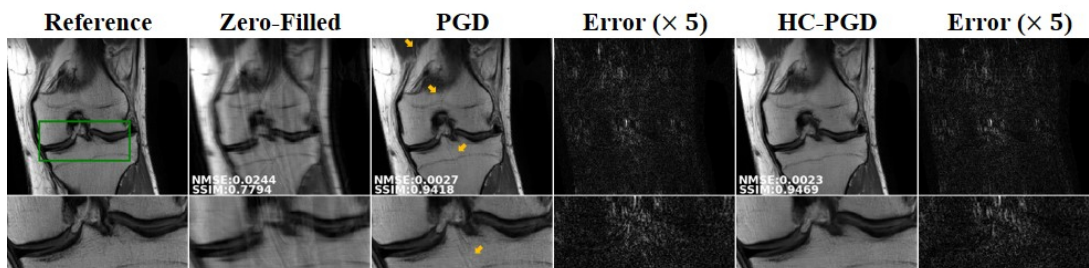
Results of changing the proximal operator CNN, with a slice from the Coronal PD dataset with 4-fold uniform undersampling, reconstructed with DL-MRI reconstruction using the PGD and HC-PGD methods unrolled in a network with a U-Net design for the proximal operator units, along with Error images ($\times 5$), with the green rectangle marking the zoom-up area. Similar to the ResNet experiments, the proposed HC-PGD outperforms PGD in suppressing visible residual artifacts.
